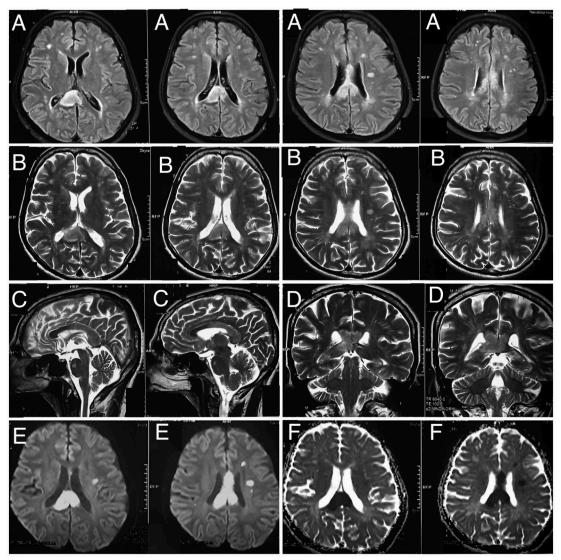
MRI images (A) FLAIR Axial, (B) T2 Axial, (C) T2 sagittal, (D) T2 Coronal demonstrate high signal and swelling of the posterior corpus callosum. There are multiple focal lesions involving the periventricular and deep white matter of the frontal lobes. (E) and (F) DWI and ADC images shows diffusion restriction in the involved corpus callosum.
